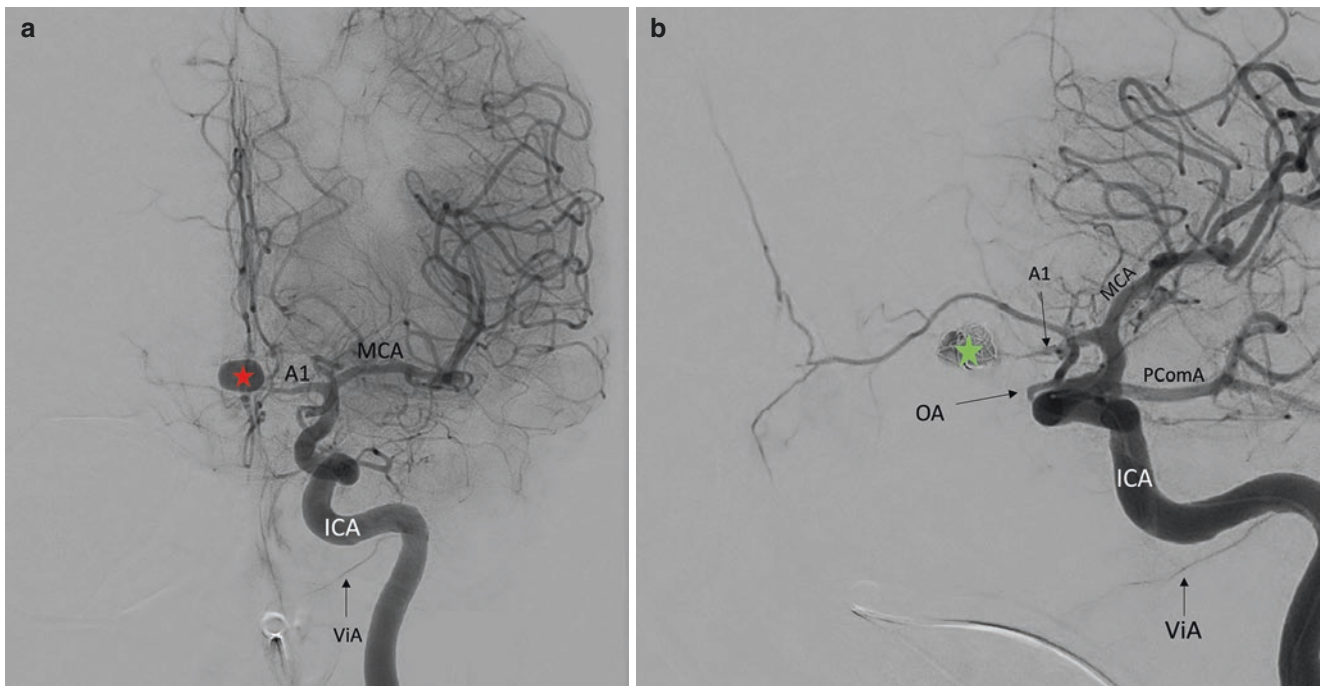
DSA showing the vidian artery. The figure shows the case of a patient who arrived to our emergency department after unusual headache and the CT scan showed a subarachnoidal hemorrhage associated with multiple aneurysms. The image shows an antero-posterior (a) and lateral (b) DSA view after left internal carotid artery (ICA) injection. In Figure a and b, the first visible branch of the ICA is the vidian artery
